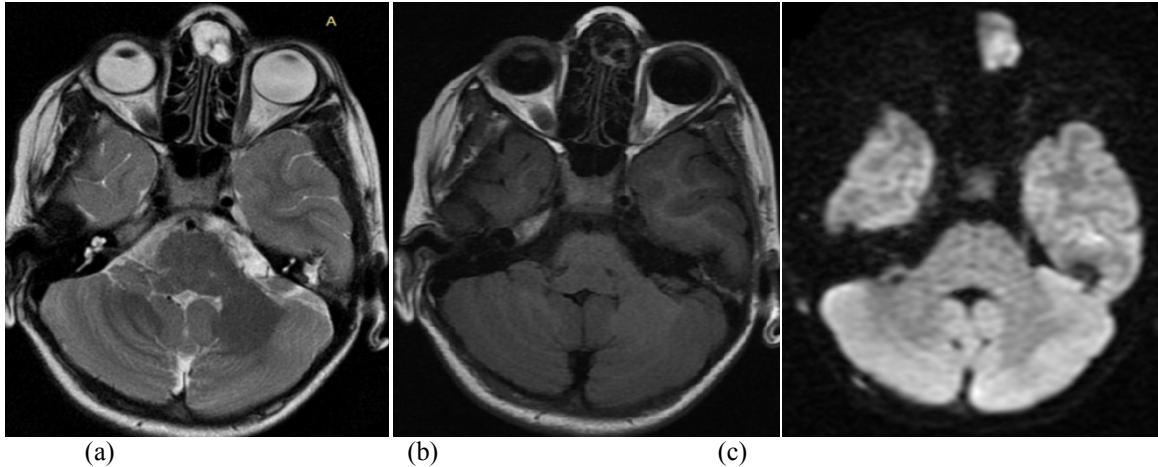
(a,b,c)Axial MRI images(T2,T1 and Diffusion weighted images respectively) showing well circumscribed, encapsulated, fluid signal intensity lesion with diffusion restriction on DWI seen in fronto-nasal region in the midline.
